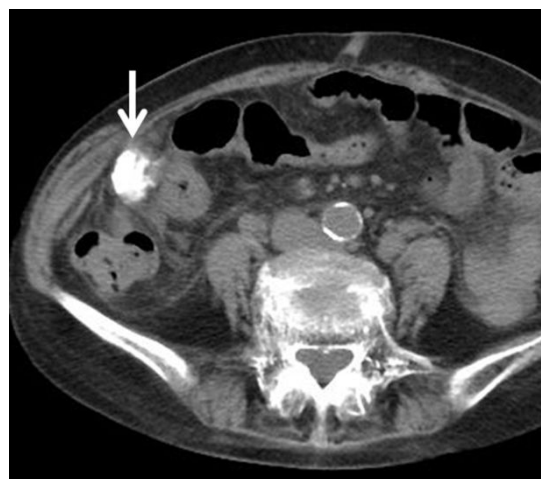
Abdominal CT; Unenhanced CT imaging shows dense accumulation of LE in the peritoneal HCC metastasis the day after B-TACE (white arrow).
